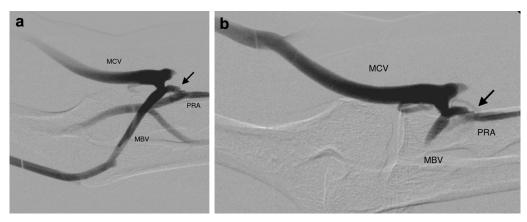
A fistulogram demonstrates successful modification in access outflow to the targeted median cephalic vein (MCV) by ligation of the median basilic vein (MBV). (a) The thermal resistance anastomosis device percutaneous arteriovenous fistula (AVF) anastomosis between the perforating vein (arrow) and proximal radial artery (PRA) is shown with substantial outflow into the competing MBV, hindering access maturation. (b) Image obtained after MBV ligation shows all AVF flow now into the MCV, with the targeted cephalic vein now palpable and easy to cannulate. Reprinted from *Journal of Vascular and Interventional Radiology*, volume 29, Hull JE, Jennings WC, Cooper RI, et al. The pivotal multicenter trial of ultrasound-guided percutaneous arteriovenous fistula creation for hemodialysis access, pages 149–158, Copyright © 2018, with permission from Elsevier.²⁴
